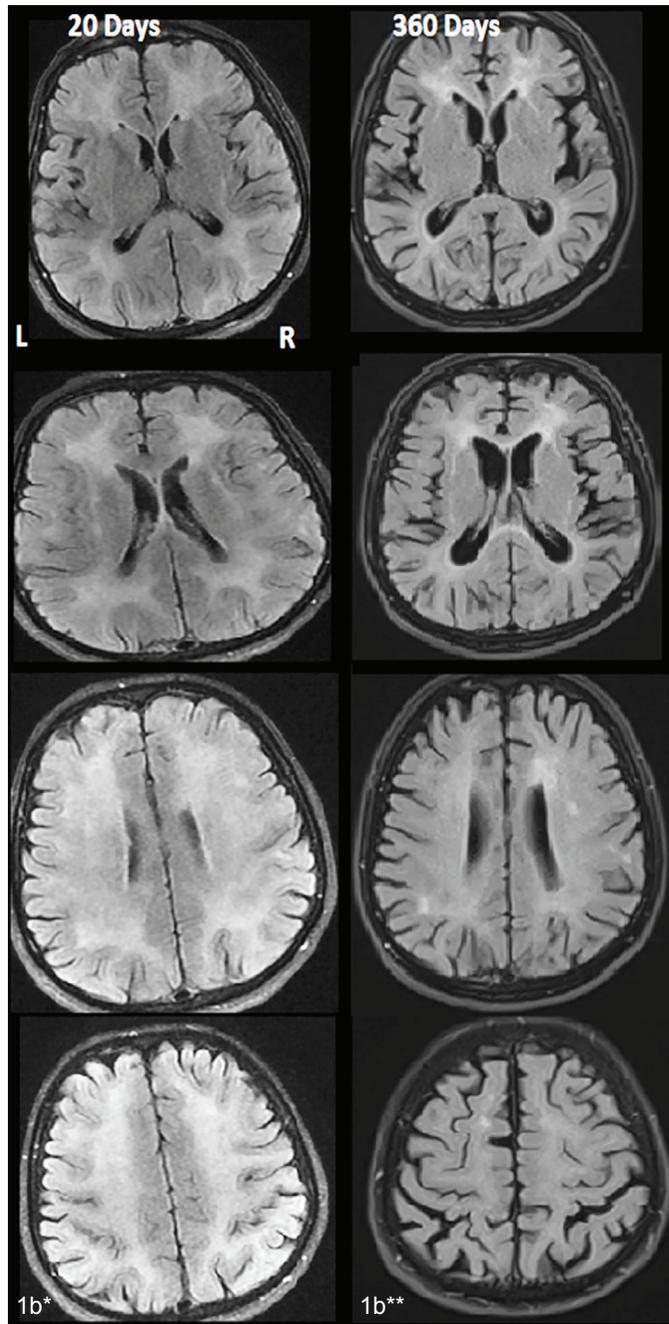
Bilateral globus pallidus lesions, periventricular and deep white matter hyperintensities were seen on MRI 20 days after the first event (Figure 1b*) and regressed after 1 year (Figure 1b)
